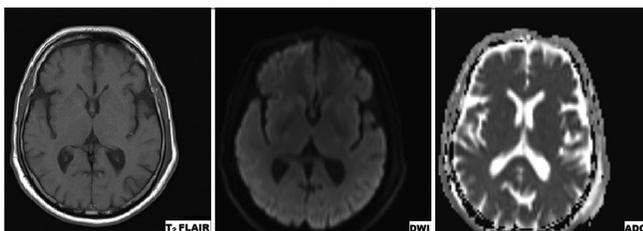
Magnetic resonance imaging brain showing no structural changes
